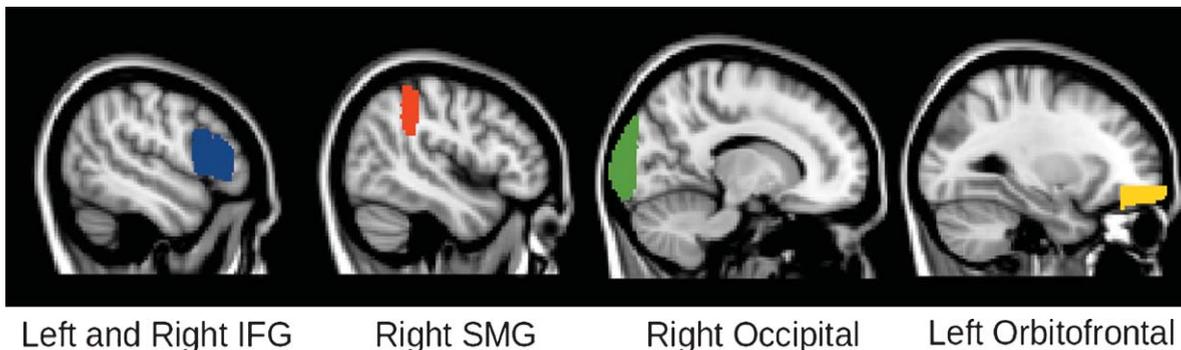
The left and right IFG (Blue), right SMG (Red), right occipital (Green), and left orbitofrontal (Yellow) ROIs used to extract blood flow values are shown overlaid on T1-weighted images.
